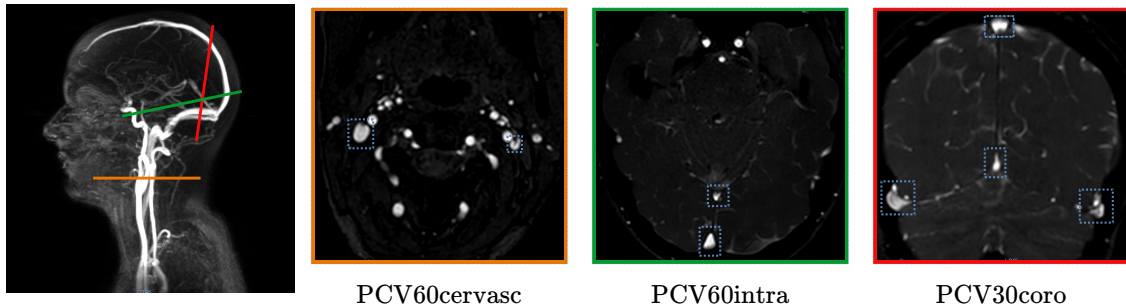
Location of the PC-MRI slices for T2 and the corresponding amplitude images.
